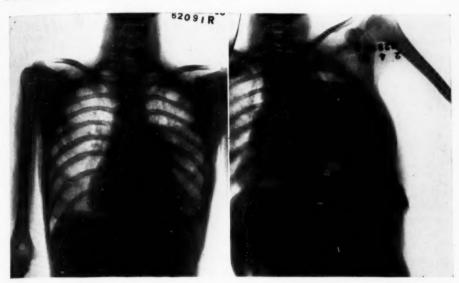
X-ray January 3, 1930, three weeks before admission.
